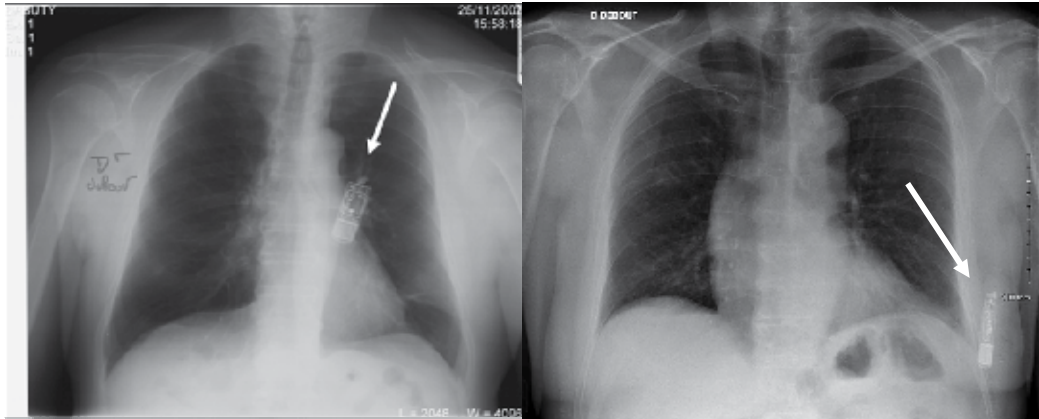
Left. Anteroposterior chest radiography displays Reveal in a usual site. Right. Chest radiography shows Reveal inserted in a left axillary site in a young girl.
